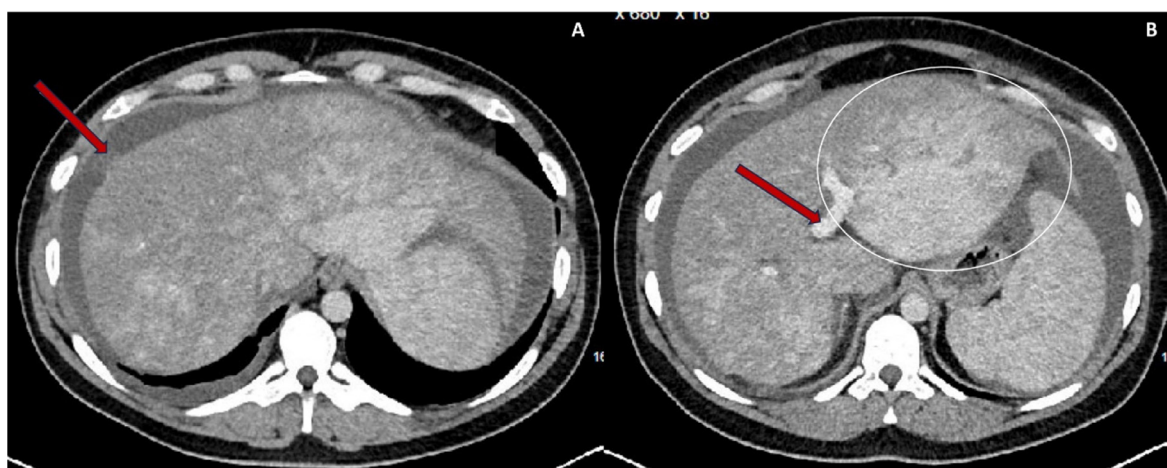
(A) Axial portal venous phase CT of the upper abdomen demonstrating the “nutmeg appearance” of the liver parenchyma, with no discernible hepatic venous flow. Perihepatic ascites is noted (Red arrow). (B) Axial portal venous phase CT of the upper abdomen demonstrating that the portal vein is patent (Red arrow). There is hypertrophy of the left lobe (white circle).
